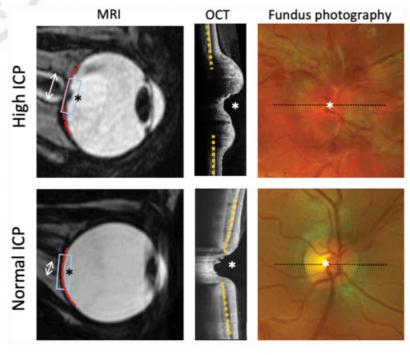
Findings associated with intracranial hypertension (top) compared with normal ICP (bottom) on ancillary testing, including MRI (left), OCT (center) and fundus photography (right). Box on MRI indicates region of OCT. Dashed line on fundus photography indicates cross-section of OCT. Optic nerve head (*), optic nerve sheath width (double arrow), globe flattening (red dashed line), and eye shape change (yellow dashed line).
